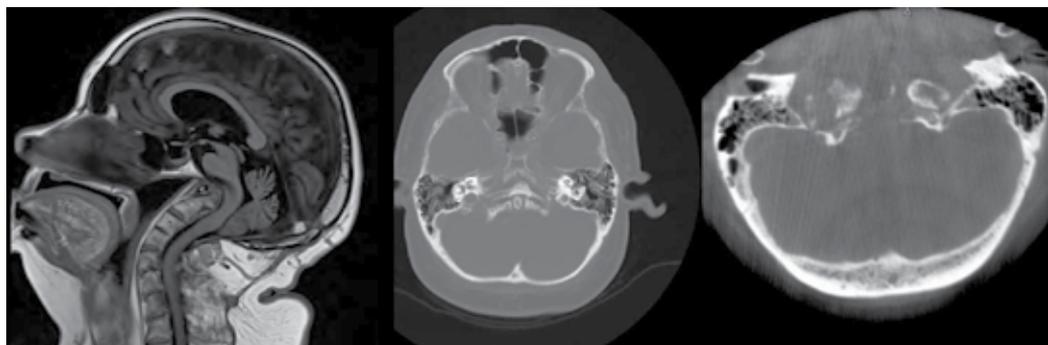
Preoperative Sagittal T1-weighted MRI and axial CT scan; and axial post midline decompression O-Arm image (sagittal reformatted images show complete decompression from clivus to C2/3 level) in 44 year old myelopathic female with platybasia and basilar invagination with brainstem compression, treated via endoscopic approach with O-Arm assisted navigation.
